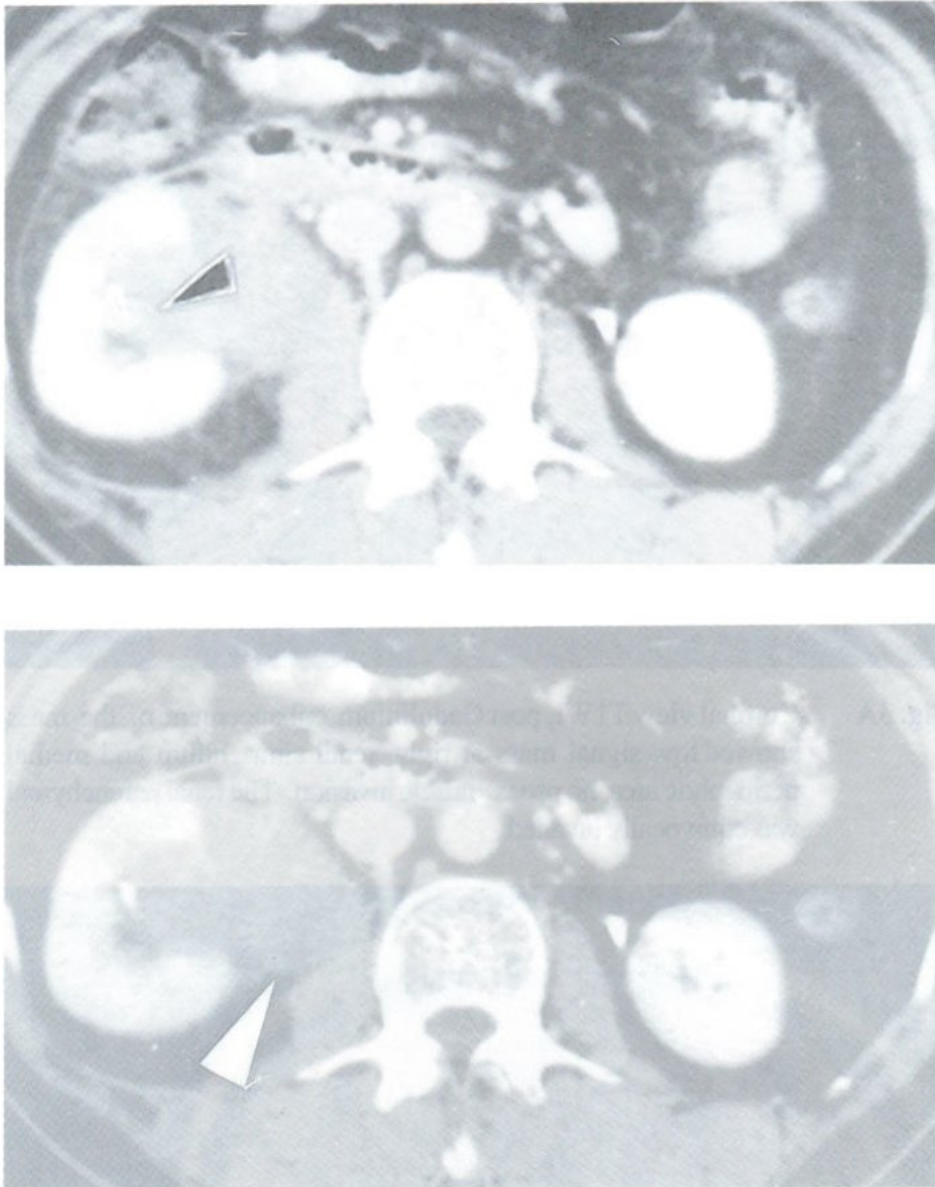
I.V. contrast enhanced CT scan revealed an infiltrative border solid mass at right renal hilum, extending to renal sinus and medial perinephric tissue.
